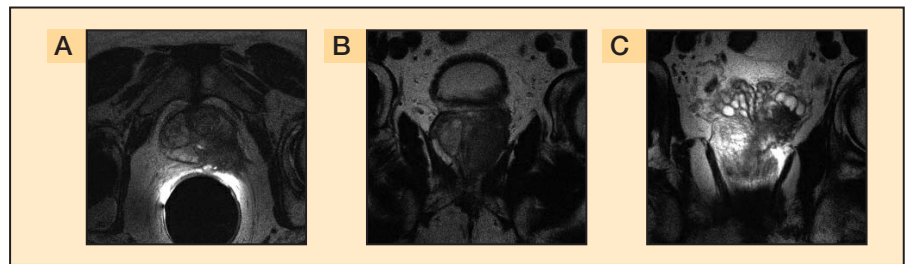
Staging endorectal MRI at time of prostate cancer diagnosis. (A) Evidence of left extraprostatic extension with invasion to the region of the left neurovascular bundle. The tumor appears darker than the remainder of the prostate on T2-weighted image. The leading edge of the cancer is irregular and is seen infiltrating into the periprostatic fat. (B) A coronal section demonstrates cancer within the entire left lobe and significant bulge of the capsule. (C) The tumor also exhibits seminal vesicle invasion.
